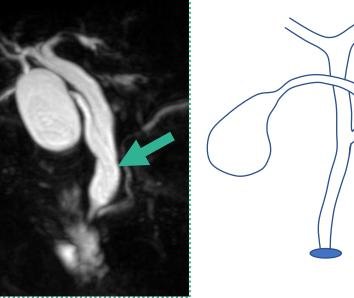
Magnetic Resonance Imaging showing the medial cystic duct insertion, passing anterior to the common hepatic duct.
